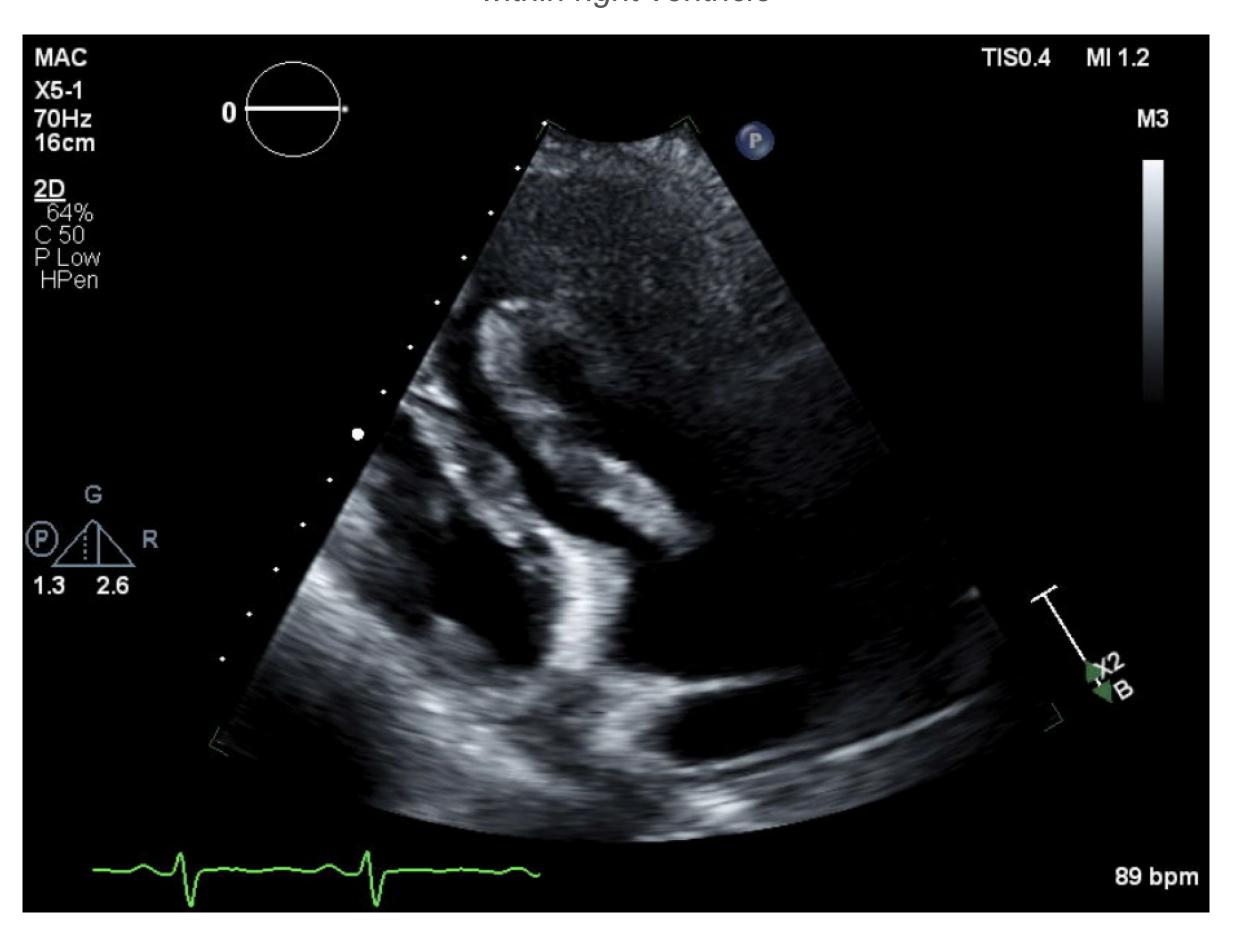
Parasternal long axis view echocardiogram showing mobile mass within right ventricle
